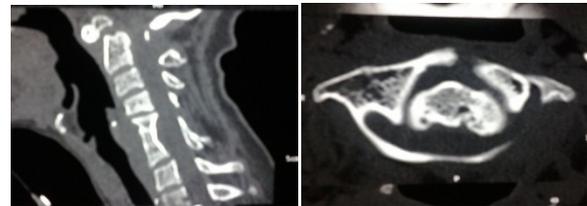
CT scan showing fracture dens with anterior displacement
